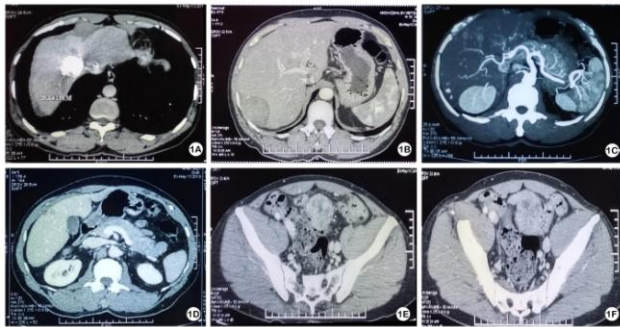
CT scan result: A natural hypodense mass with 39 x 41 mm located in segment IV – VIII
